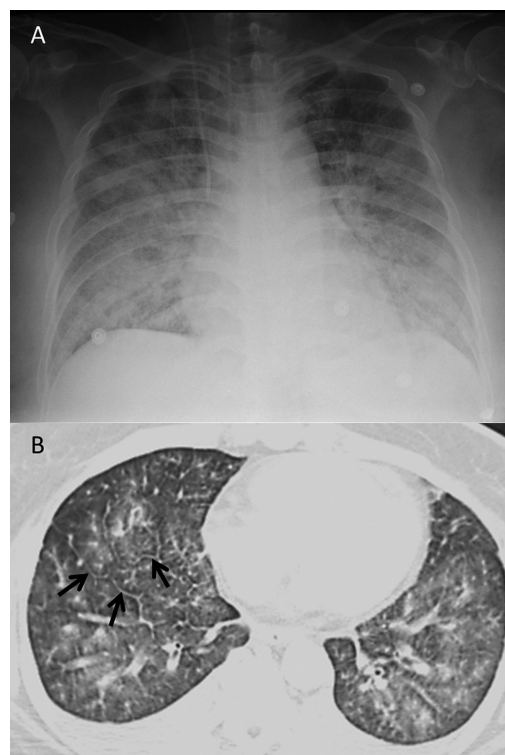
(A) Chest X-ray showing patterns of pulmonary edema. (B) CT scan showing thickened interlobular septum (arrows) mixed with ground glass opacities distributed along the bronchovascular bundles.
